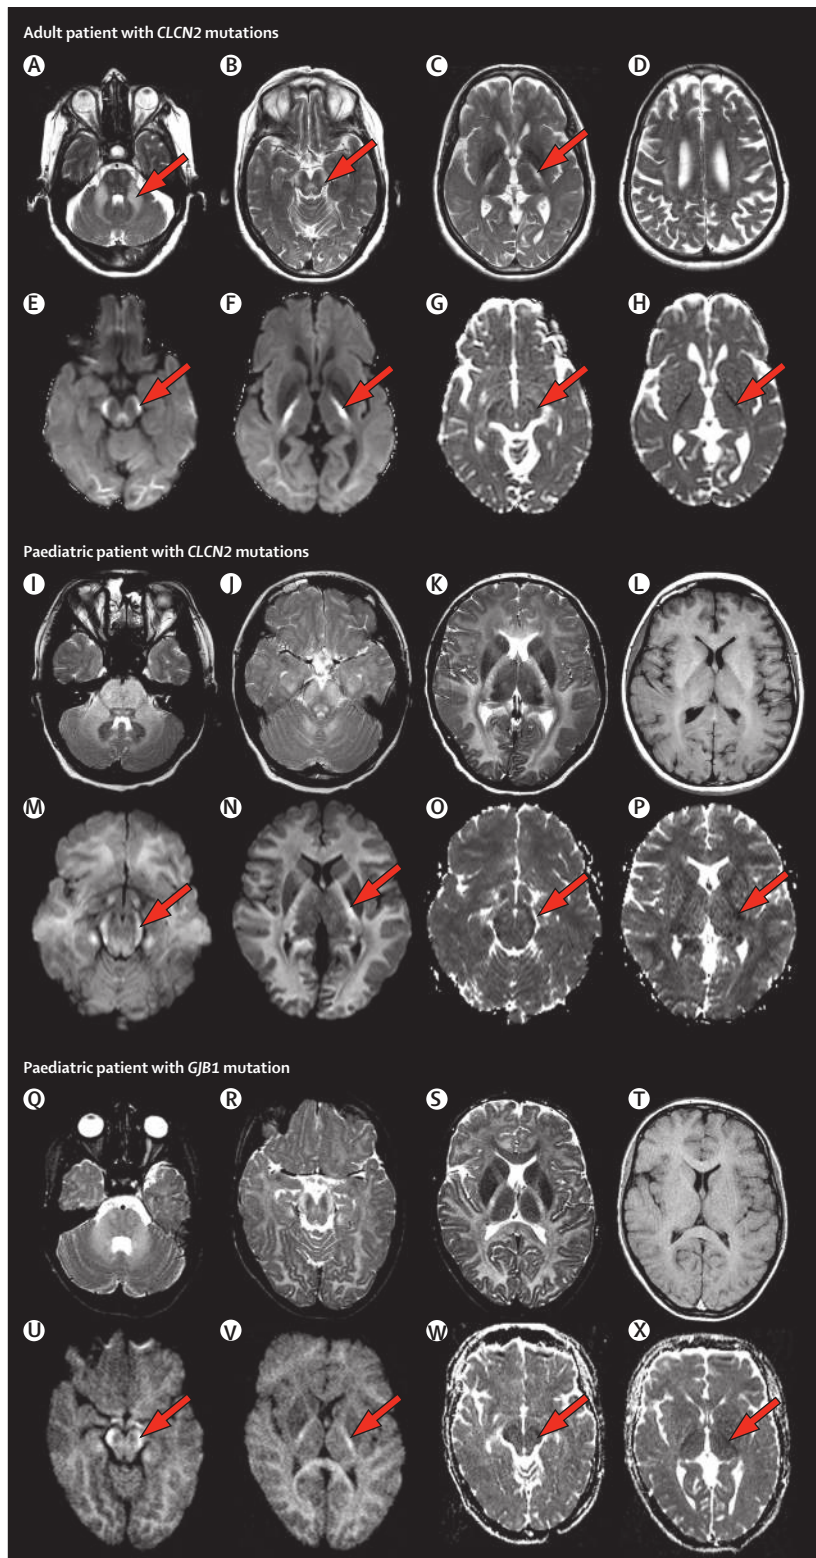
MRI of brain in patients 1, 4, and 7
